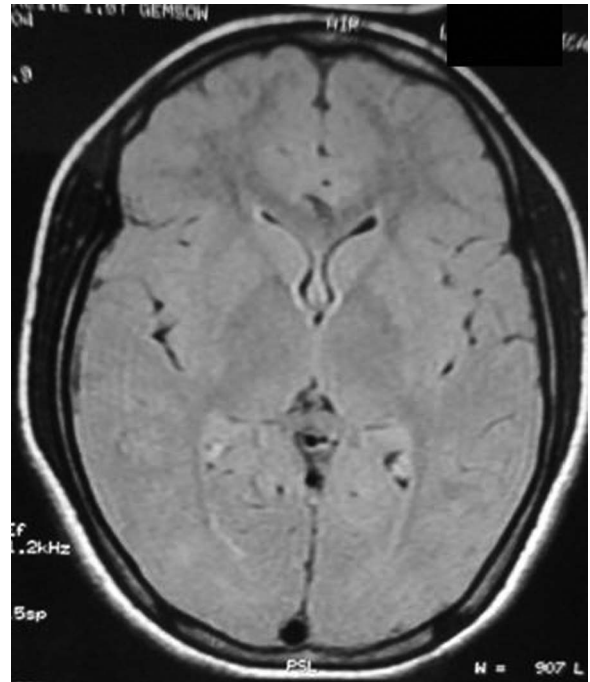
Initial MRI brain T2 fluid-attenuated inversion recovery sequence showing no obvious abnormality.
